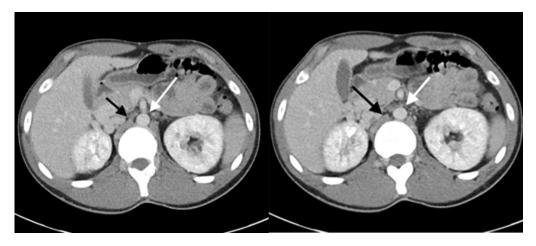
Axial CT venogram of the abdomen showing the absence of the suprarenal IVC (the black arrow). The white arrow demonstrates the abdominal aorta.
